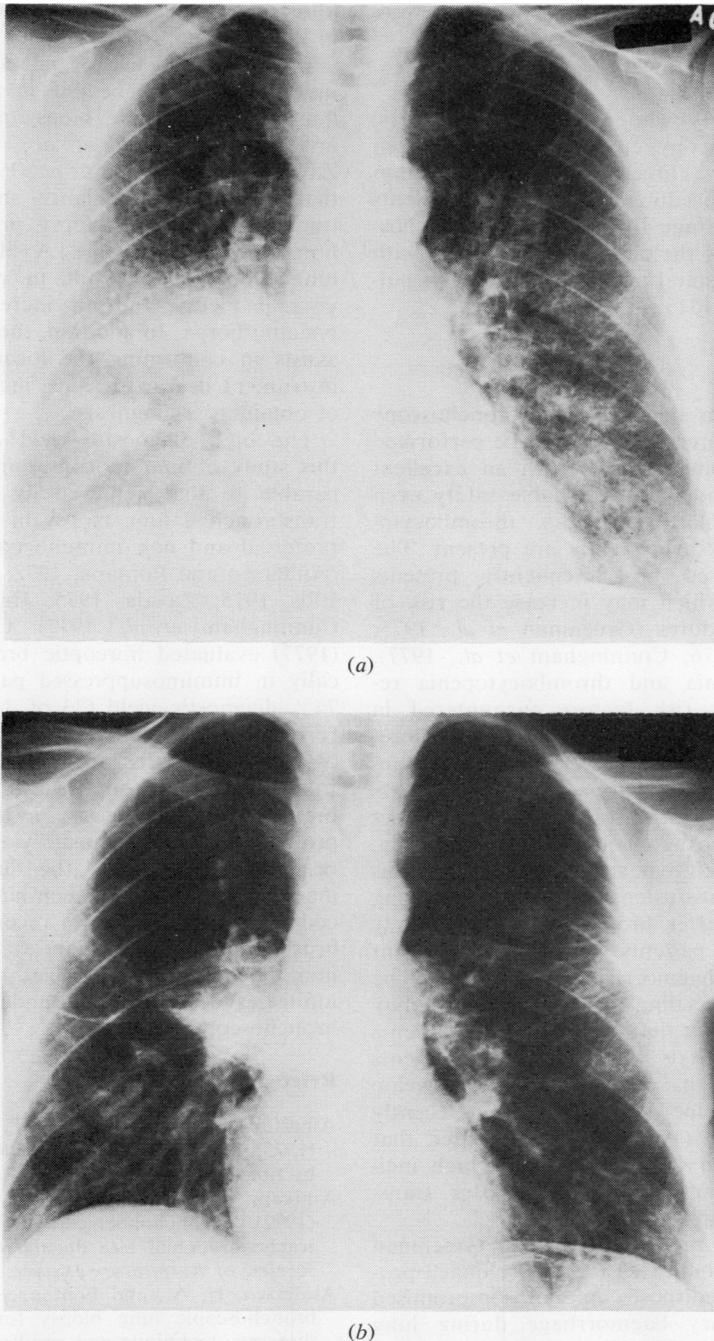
Chest radiographs of a 52-year-old woman (MM) with erythroleukaemia receiving cytotoxic chemotherapy. Brush and transbronchial forceps lung biopsies revealed *Aspergillus flavus*, and *Aspergillus precipitans* rose from a titre of 1:8 to 1:32: (a) shows diffuse, bilateral infiltrates; (b) after four weeks' therapy with amphotericin B and rifampicin reveals considerable clearing of the pulmonary infiltrates.
